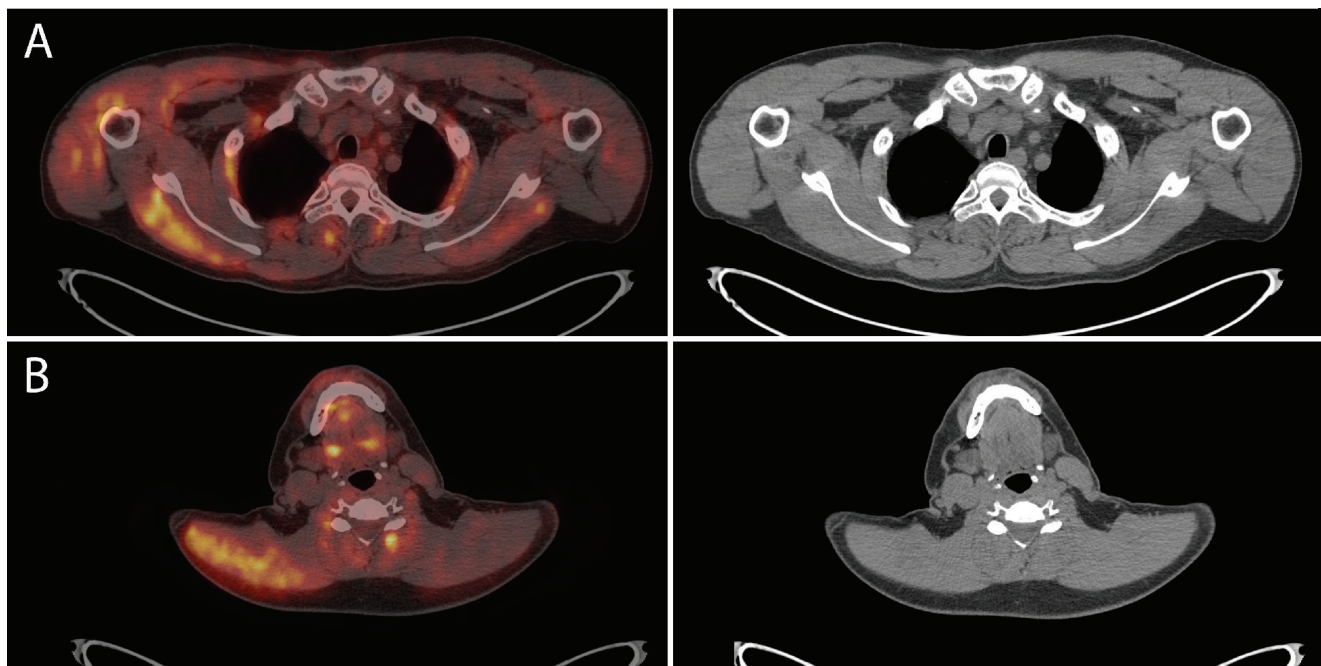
Right biceps muscles showed increased ¹⁸F-FDG uptake with SUV_{max} 5.0, (A) right shoulder muscles had SUV_{max} 4.0, (B) right trapezius muscle had SUV_{max} 4.1 and right serratus anterior muscle had SUV_{max} 3.8.
